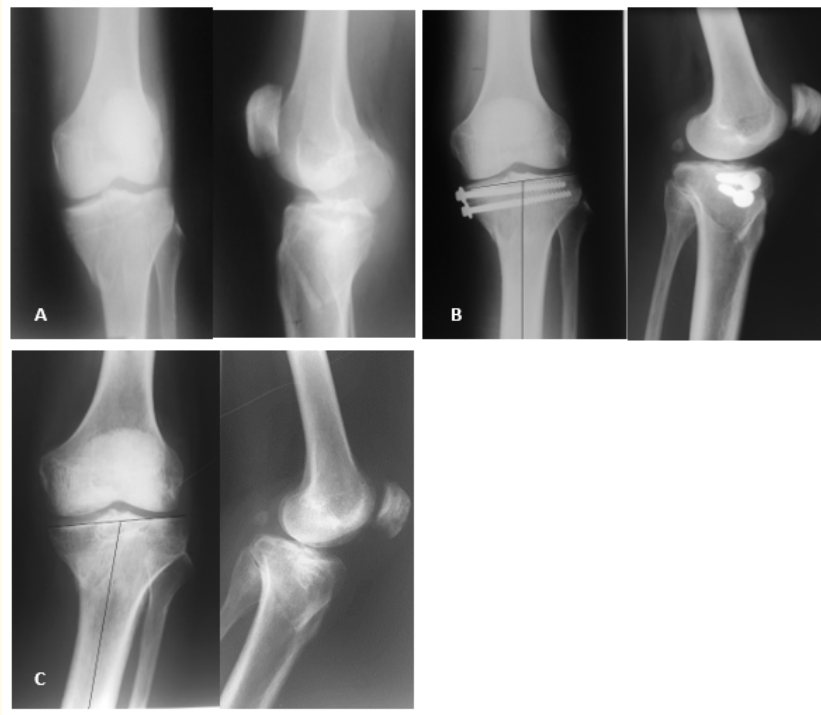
Schatzker IV tibial plateau fracture in a 61-year-old diabetic patient following a domestic fall accident (A). He had surgery with percutaneous fixation using 2 cancellous lag screws. The post-operative tibial plateau angle was 85 degrees (B). Implant removal was done 6 months after surgery following implant failure. On the latest follow-up, 4 years after surgery, radiographs have shown condylar widening and varus deformity with a tibial plateau angle equal to 75 degrees (C). Physical examination revealed varus deformity to the operated knee. The Rasmussen clinical assessment score was 24 and the modified Rasmussen radiological
